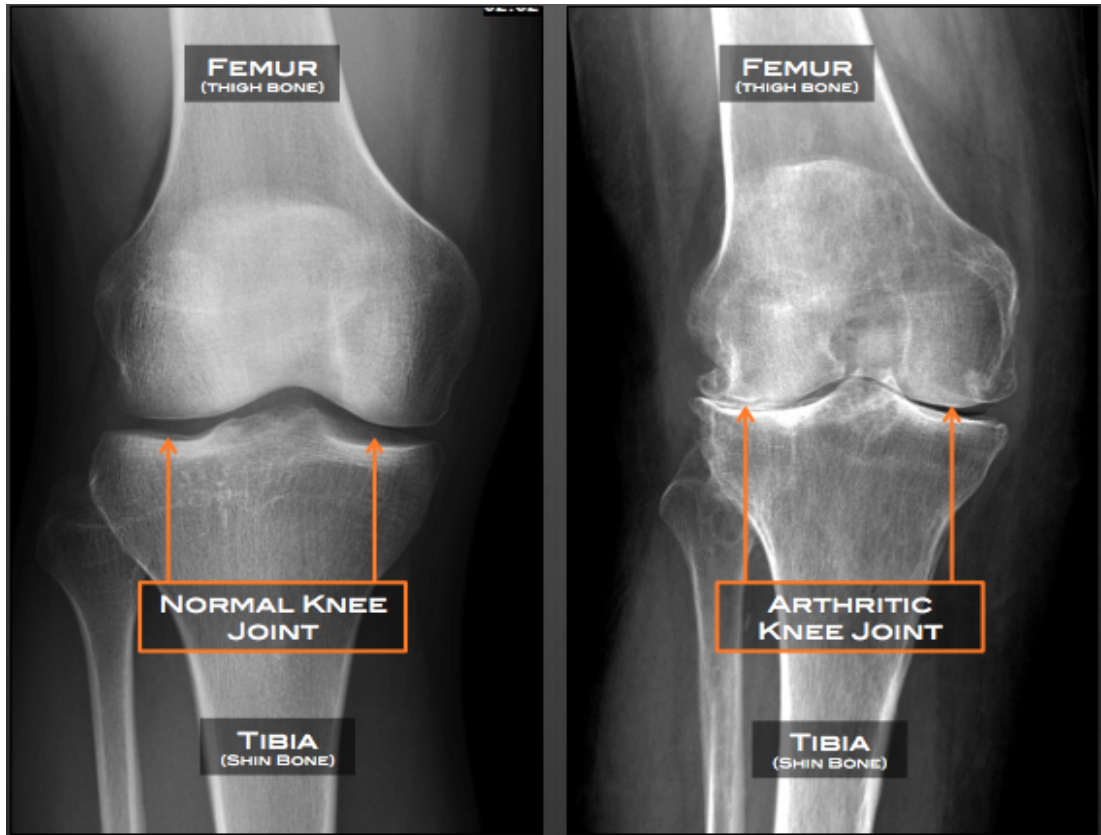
Joint space narrowing using X-rays ([Driscoll](#))
